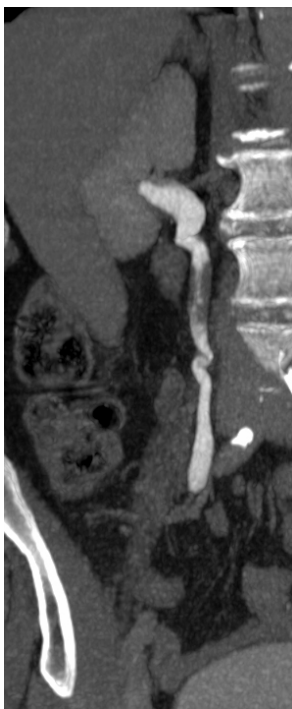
Coronal reconstruction of the excretory-phase CT urogram and a corresponding retrograde ureteropyelogram showing a sessile urothelial carcinoma
